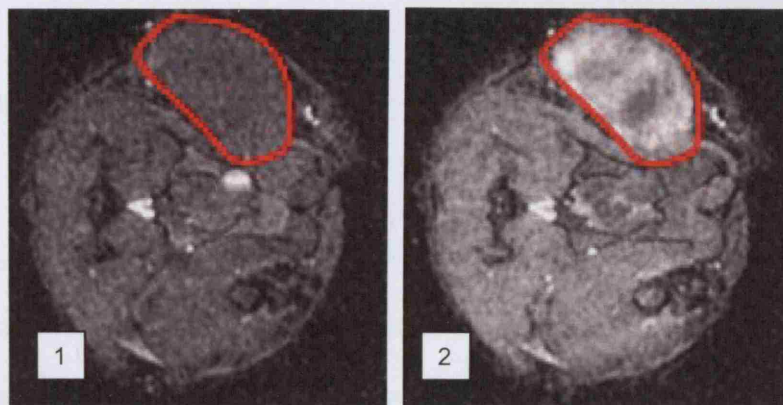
Gadolinium-enhanced MRI image through mid-axial section of P22 tumour model. The tumour is outlined. The images were acquired 0 seconds (image 1) and 90 seconds (image 2) after the beginning of Gadolinium infusion. Image 2 shows the relatively greater increase in tumour signal intensity from the Gadolinium.*
